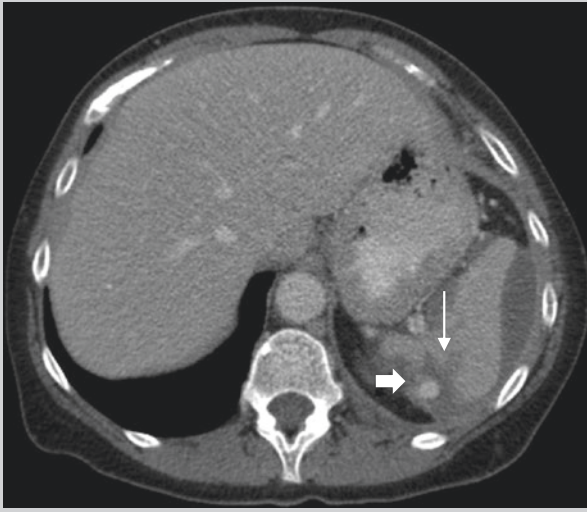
Contrast enhanced CT of the upper abdomen showing a splenic laceration with contained perisplenic haematoma (*arrow*) and pseudoaneurysms arising from distal splenic arterial branches (*thick arrow*)
